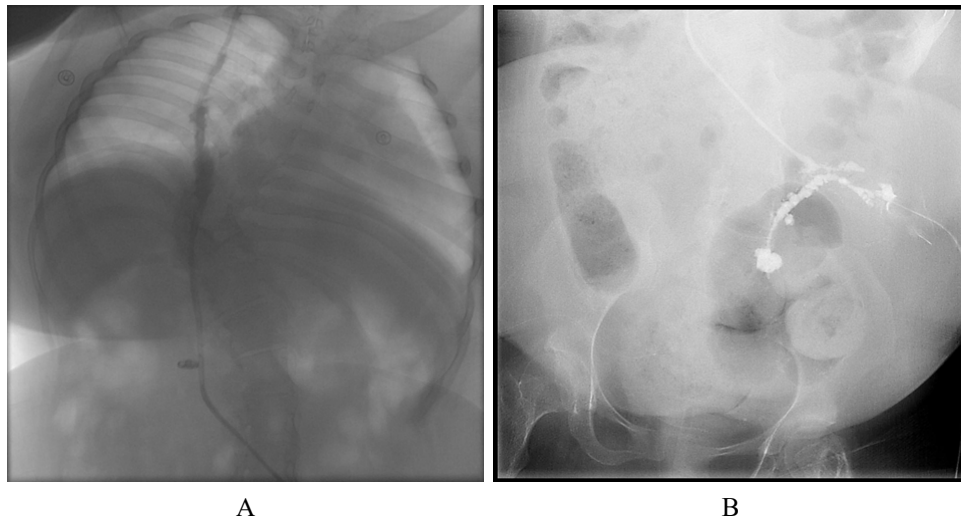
(A) Chest X-ray and (B) pelvic X-ray demonstrating contrast opacification of the ventriculoperitoneal (VP) shunt catheter along its expected course. The shunt system is visualized on both images without radiographic evidence of disconnection on the shunt series.
